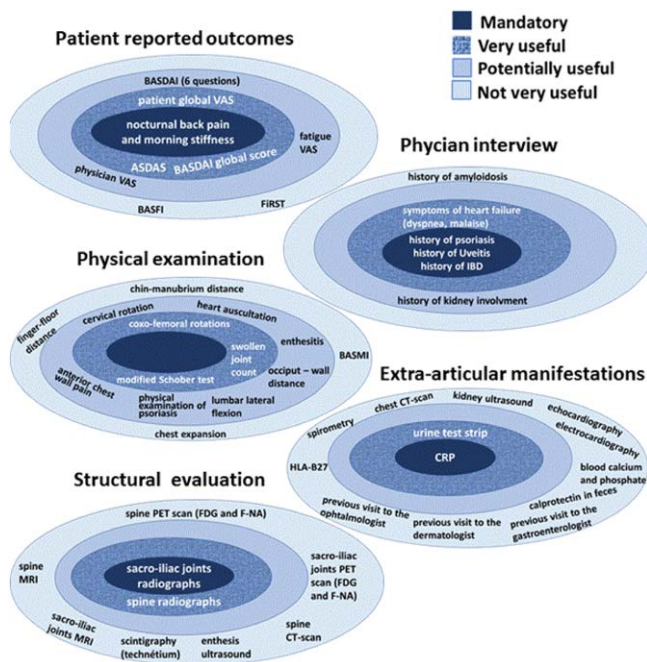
Core sets of items to collect and report in the systematic review in axial spondyloarthritis management in daily practice ASDAS=Ankylosing Spondylitis Disease Activity Score, BASDAI=Bath Ankylosing Spondylitis Disease Activity Index, BASFI=Bath Ankylosing Spondylitis Functional Index, BASMI=Bath Ankylosing Spondylitis Metrology Index, CRP=C Reactive Protein, CT=computerized tomography, FIRST=Fibromyalgia Rapid Screening Tool, HLA=Human Leukocyte Antigen, MRI=Magnetic resonance imaging, PET=positron emission tomography.
